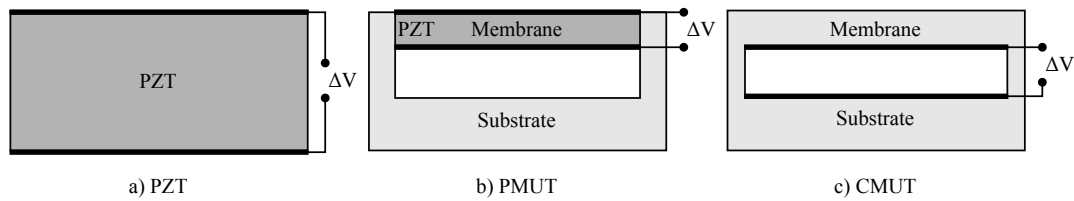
a) Piezoelectric transducer. The deformation in the crystal lattice generates a difference in potential. b) Piezoelectric Micromachined Ultrasonic Transducer. The deflection of the membrane deforms the PZT generating a voltage difference. c) Capacitive Micromachined Ultrasonic Transducer. The deflection of the membrane generates a change in capacitance between substrate and membrane, which can be detected as a voltage or current difference.
